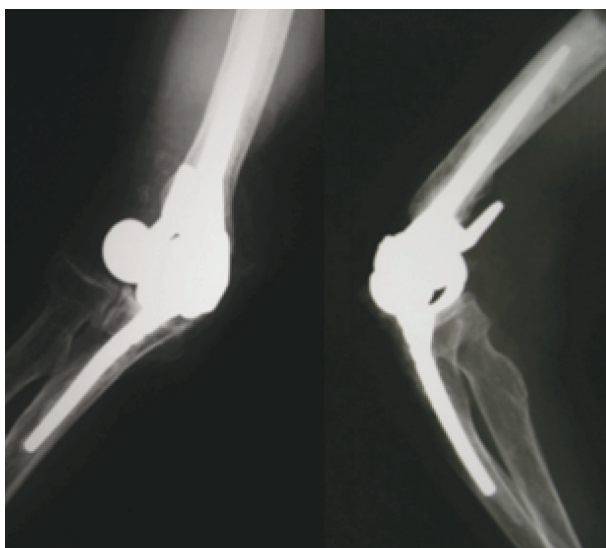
Postoperative X-rays of Latitude implant; grade 1 PE-Morrey criteria.
